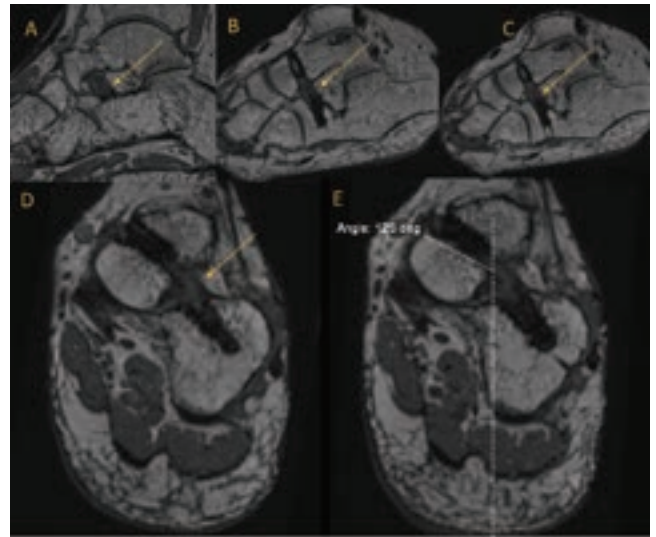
to 9E. Volumetric post-operative MRI images (22 months after surgery): Reconstructed coronal and sagittal images manually optimized to be parallel with the graft. The coronal slices were obtained using a 45-degree caudal tilt in the sagittal plane (9A to 9C), and the sagittal slices were obtained using a 55-degree medial tilt in the coronal plane (9D and 9E): Reconstructed sagittal image 125 degrees showed intact cervical ligament graft.
